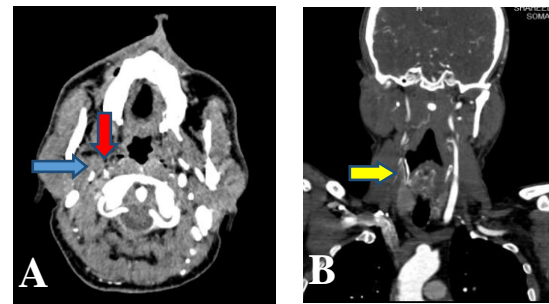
A-The axial cut of CT angiography related slide at the level of c1 above the level of common carotid bifurcation, showing the low blood flow in right internal carotid artery (red arrow) and external carotid artery (blue arrow). B-The coronal view of carotid artery, demonstrating diffuse carotid thrombosis and occlusion in common carotid artery (yellow arrow).
